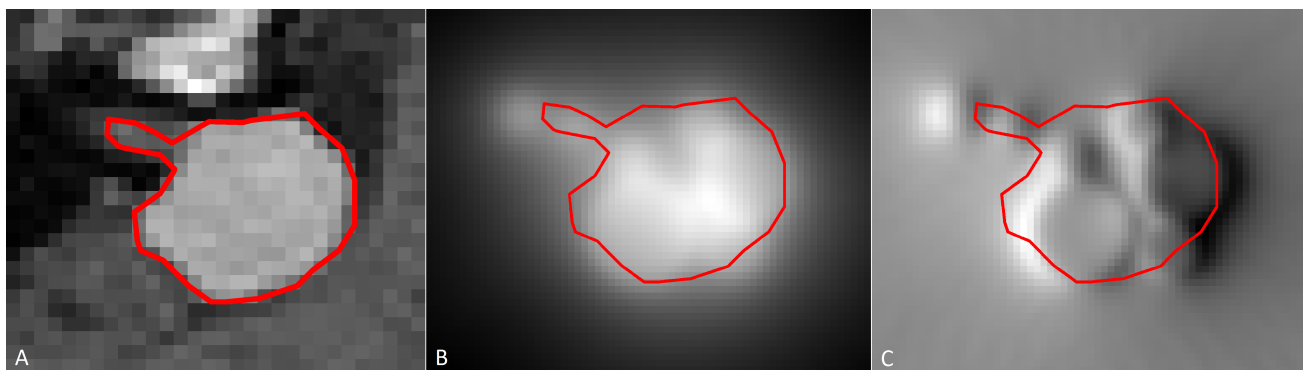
Image examples of the data. The contouring determined by the neurosurgeon during treatment planning is superimposed in red. (A) T1-weighted, contrast-enhanced MRI of a vestibular schwannoma, where the image part containing the tumor is delineated. (B) Calculated dose distribution, where the dose intensities are proportional to the gray-level intensities. (C) Gradient of the dose distribution in the x -direction. The strength of the gradient is represented by the gray-level intensities, where fully white is a strong positive gradient and fully black a strong negative gradient. The different radiation shots used in a GKRS treatment are clearly visible in this image.
